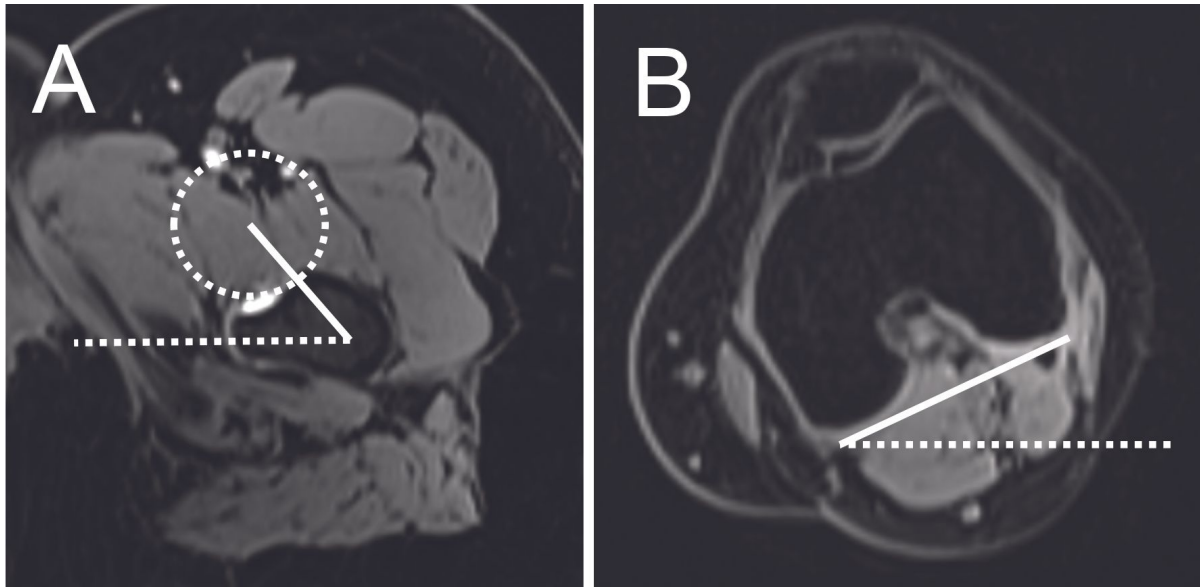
Measurement of femoral torsions. Femoral torsions can be measured by MRI or CT scan by coupling an axial section at the proximal (A) and distal (B) femur, using Murphy's method. These measurements are important because increased ($>35^\circ$) or decreased ($<0^\circ$) femoral torsions may be the cause of posterior or anterior femoro-acetabular impingement.
